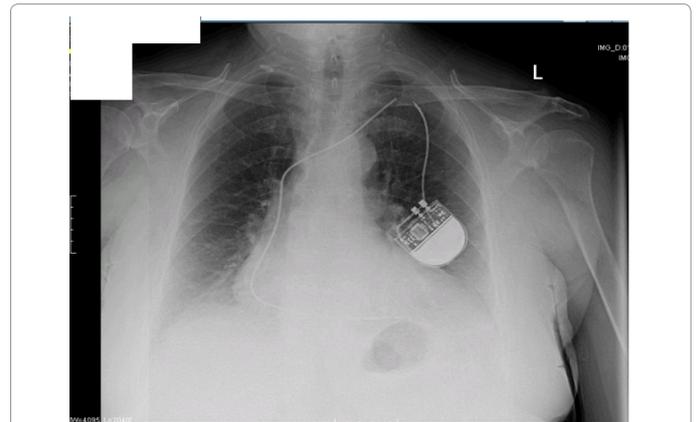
Chest X-Ray demonstrates a single-lead permanent pacemaker with a complete transection of its lead inferior to the clavicle at the level of the first rib (arrow).
